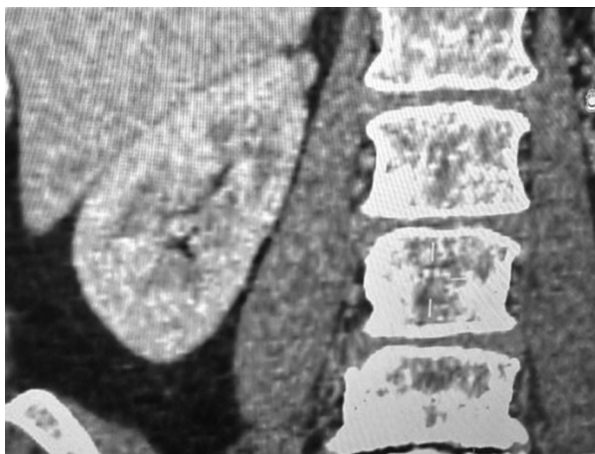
Renal mass on the upper pole, contrast-enhanced CT scan
